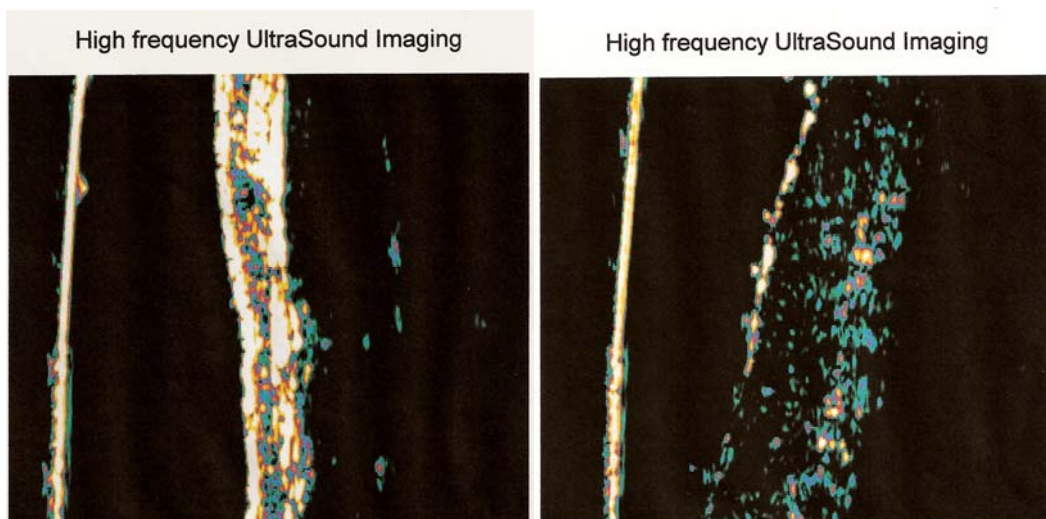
High frequency ultrasound of the skin in this patient showing solar damage. A. Control (forearm), B. Forehead.
